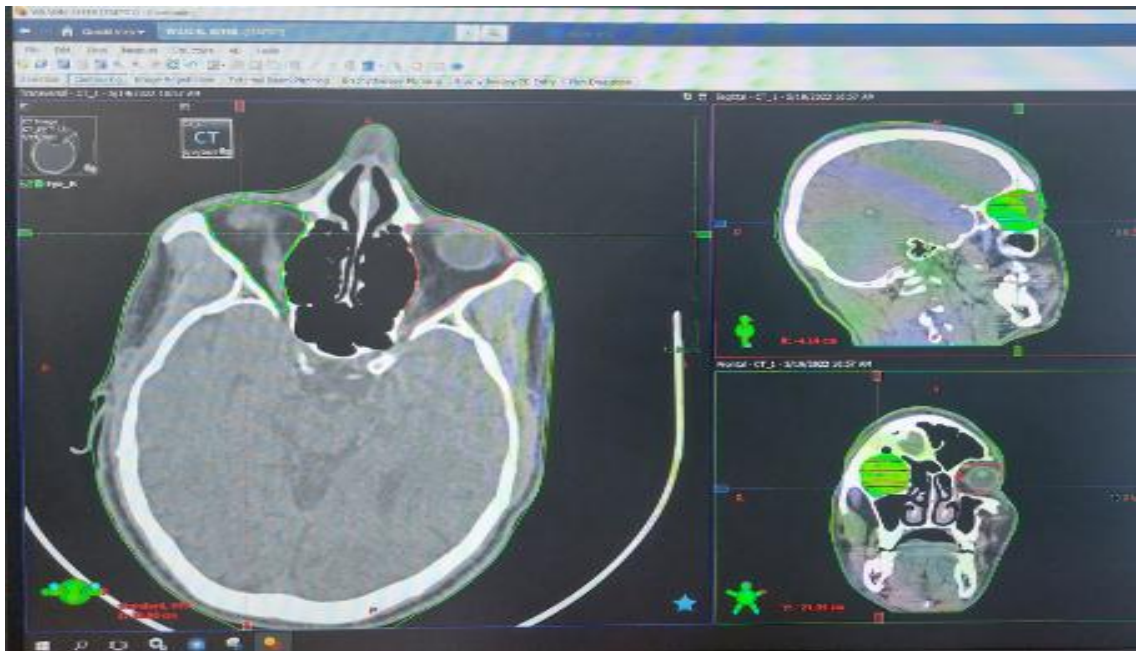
Right Orbital axial CT scan showing depth
